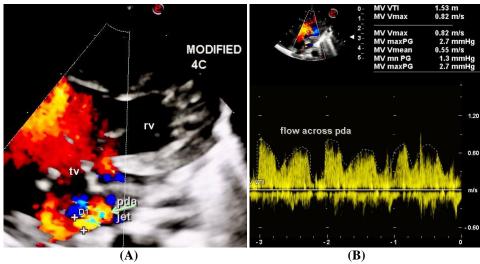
(A) Patent ductus arteriosus attaching to right pulmonary artery. pda, patent ductus arteriosus; TV, tricuspid valve; RV, right ventricle. (B) On continuous wave doppler analysis, peak and mean gradient across pda was 2.7/1.3 mmhg.
